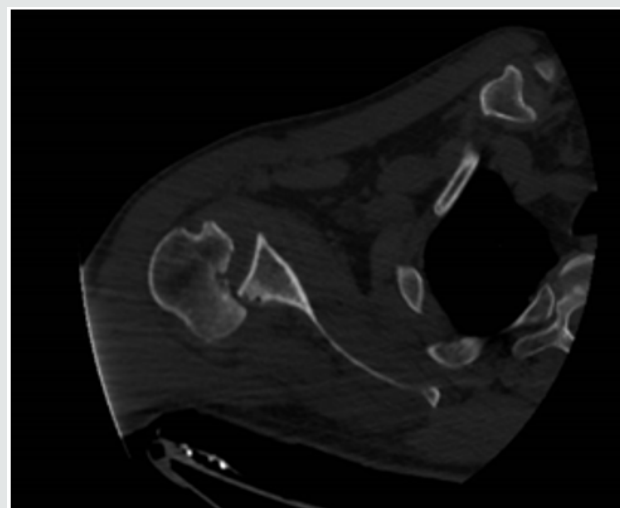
CT Scan Showing the Reverse Hill-Sachs Lesion.
